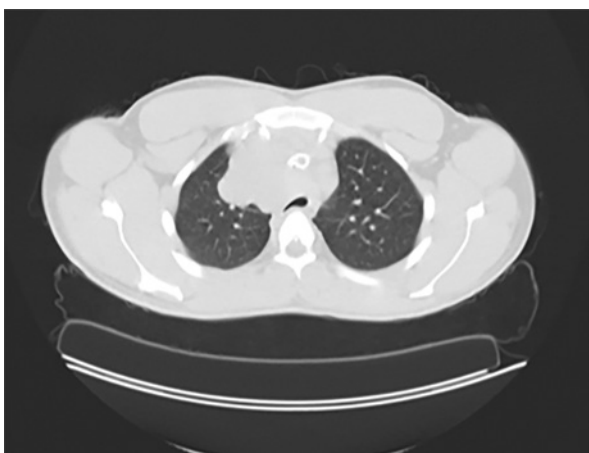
Computed tomography scan of the chest showing bulky infiltrative mass (non-Hodgkin lymphomas) extending from the anterior mediastinum to the right paratracheal space with tracheal compression.
